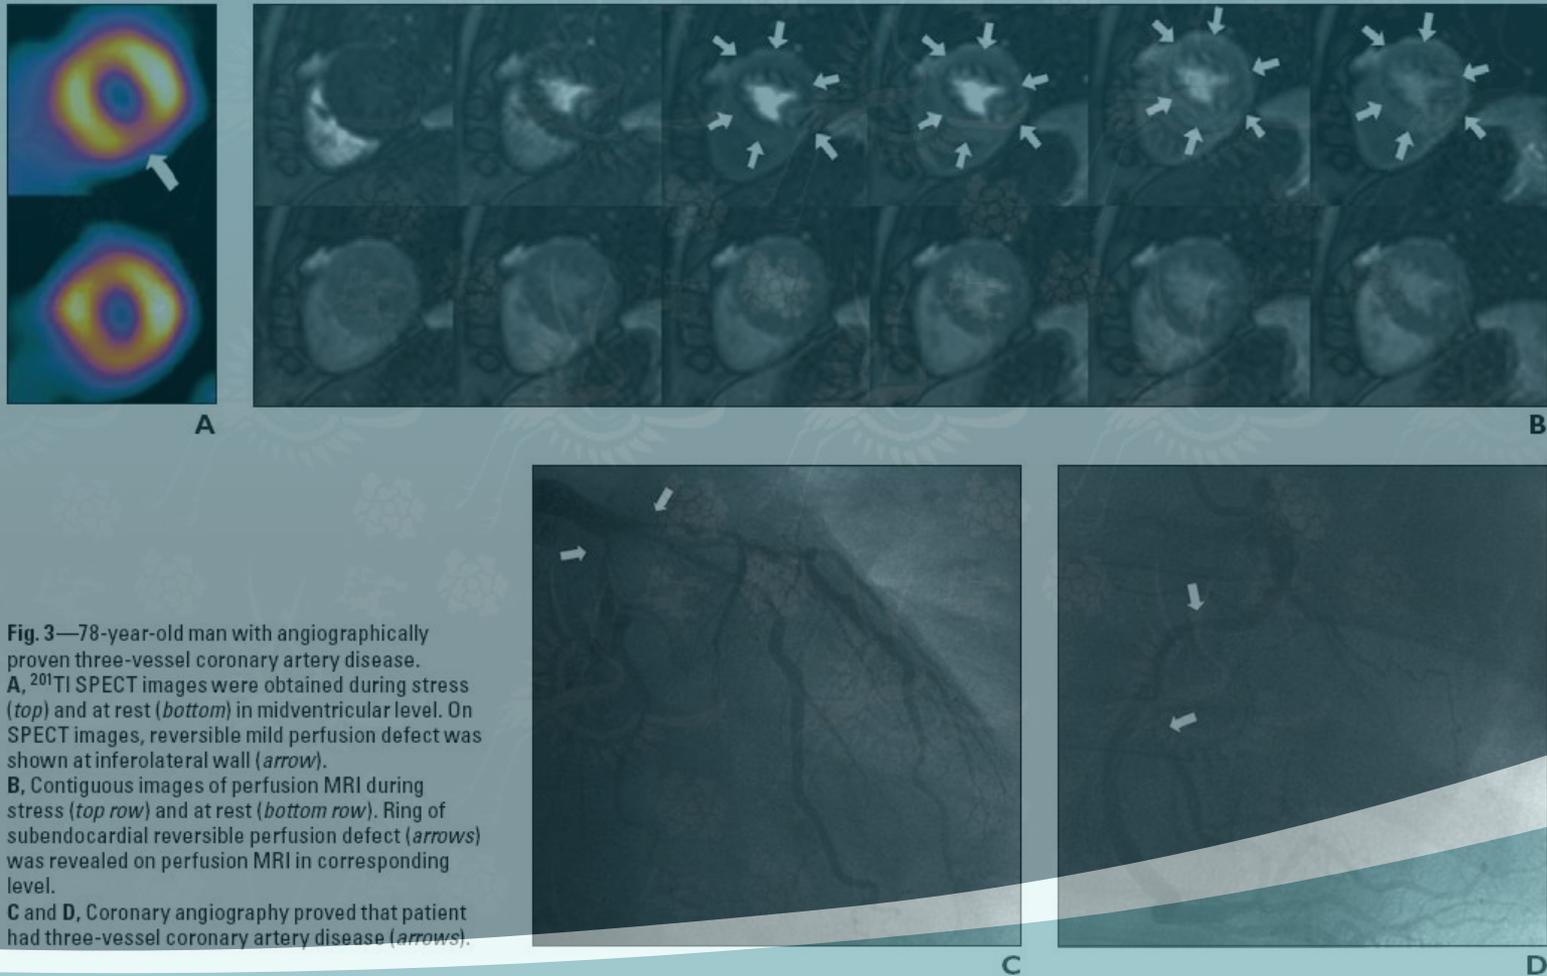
78-year-old man with angiographically proven three-vessel coronary artery disease. A, ^{201}Tl SPECT images were obtained during stress (*top*) and at rest (*bottom*) in midventricular level. On SPECT images, reversible mild perfusion defect was shown at inferolateral wall (*arrow*). B, Contiguous images of perfusion MRI during stress (*top row*) and at rest (*bottom row*). Ring of subendocardial reversible perfusion defect (*arrows*) was revealed on perfusion MRI in corresponding level. C and D, Coronary angiography proved that patient had three-vessel coronary artery disease (*arrows*).
